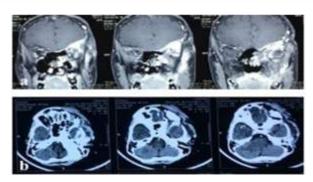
Lymphatic malformation of the left orbit and skull base. a) Pre-operative MRI T2W was showing
